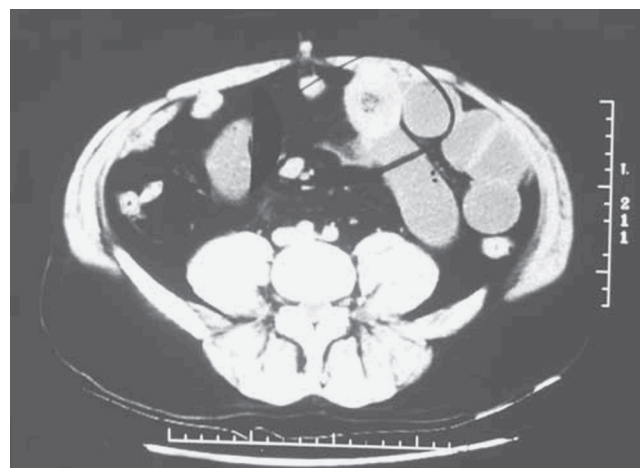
■ Computed tomographic scan from a patient with small bowel intussusception secondary to posttransplantation lymphoproliferative disease.
